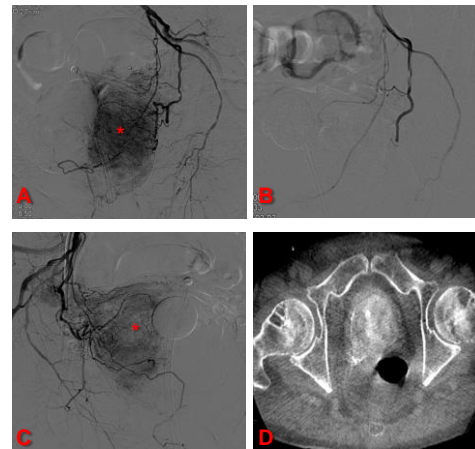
Image A, B, C and D. PAE in a 80 years-old patient that required permanent urinary catheter. Image A and C: Both IIA angiography showing the left gland blush (\* in A) and right gland blush (\* in C). Image B: Control Digital subtraction angiography (DSA) postembolization showing devascularization of left gland. Image D: Cone Beam CT after both sides embolization showing the prostate gland with rest of contrast material
